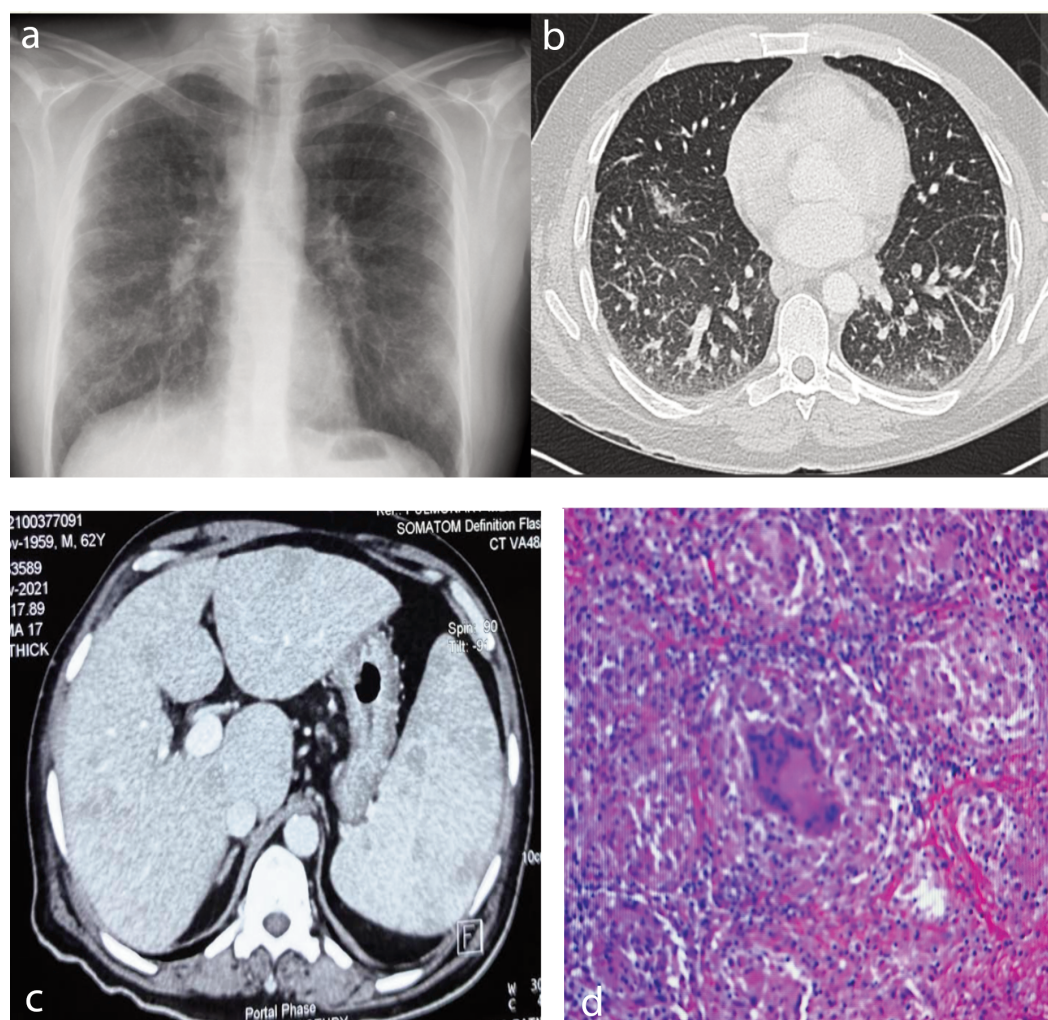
Case 2. a) Chest X-ray and b) Contrast-Enhanced Computed Tomography (CECT) of the thorax revealed bilateral lower lobe diffuse Ground Glass Opacities (GGOs) and reticulations with mediastinal lymphadenopathy. c) CECT abdomen revealed multiple small nodular hypoechoic lesions in both liver and spleen with splenomegaly, and d) transbronchial lung biopsy was taken, which showed non-necrotizing granulomatous inflammation.
